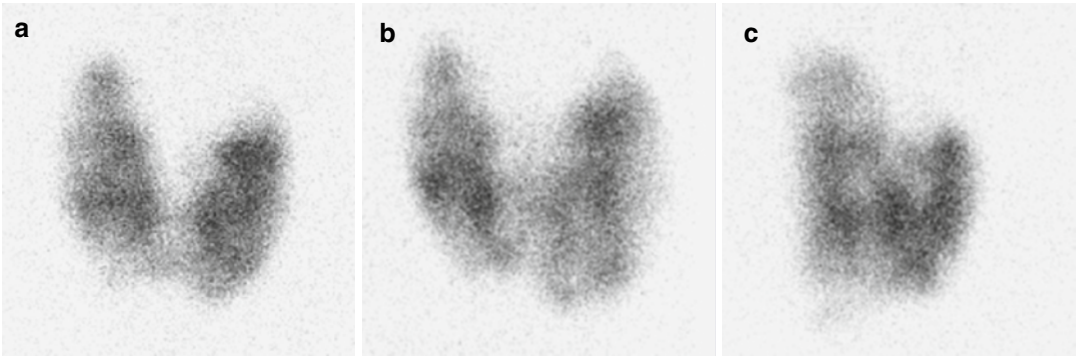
Thyroid scintigraphy in Graves' disease with inhibited radioiodine uptake. An 11-year-old girl with Graves disease previously had been treated with oral antithyroid medications and then had been in remission without therapy for 2 years. After recurrence of Graves' disease (TSH 0.009 mU/l, free T4 1.95 ng/dl), thyroid scintigraphy was performed with ^{123}I . Pinhole images acquired in the anterior (a), left anterior oblique (b), and right anterior oblique (c) projections demonstrate patchy uptake throughout an enlarged thyroid gland. Radioiodine uptake was only 14 % at 4 h and 24 % at 24 h. The uptake
